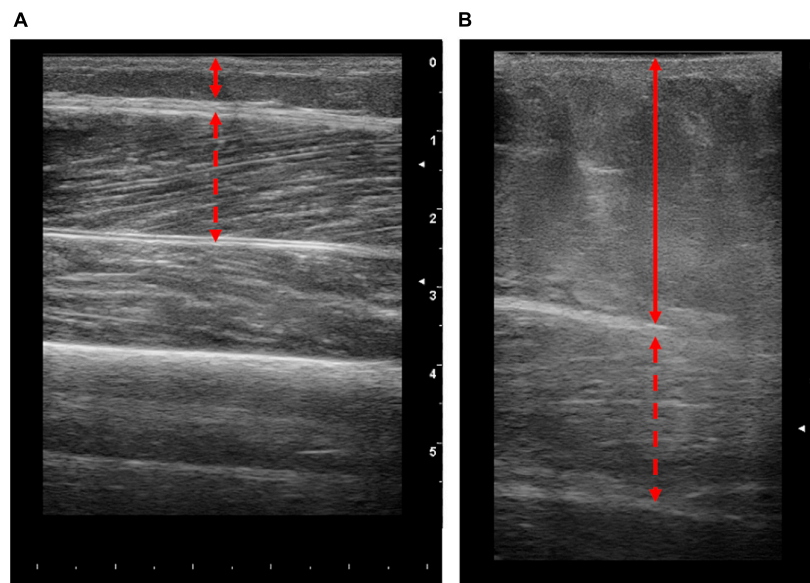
Representative longitudinal ultrasound images of the vastus lateralis (VL) from patients with end stage liver disease. Images obtained from patients with lower (A) and higher (B) body fat percentages (10.5 and 46%, respectively). Solid lines represent the thickness of adipose tissue and dashed red arrow represents the thickness of the VL. Scale on the right-hand side of each image represents cm.
